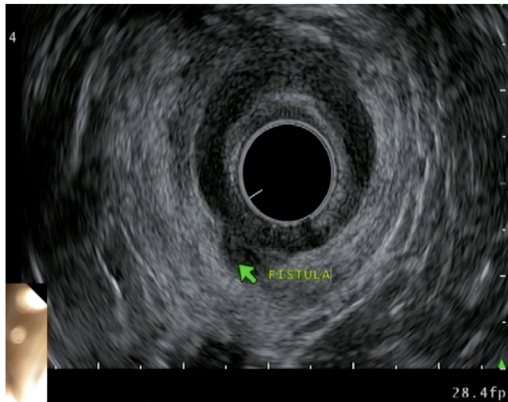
Endosonographic appearance of a low intersphincteric fistula.
